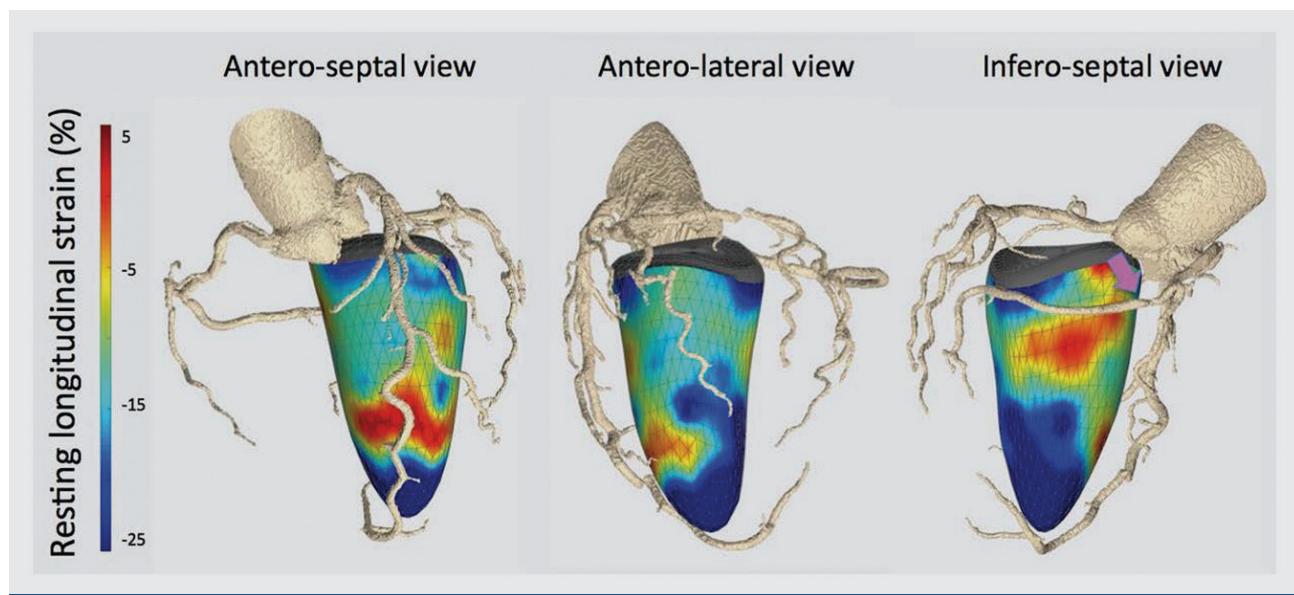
Fusion imaging of coronary CTA and three-dimensional speckle tracking echocardiography to assess the functional consequences of coronary stenosis. Combined three-dimensional displays of speckle tracking and CTA, in a patient with >70% stenosis in the mid right coronary artery (purple arrow). The infero-septal view shows reduced LV longitudinal strain in the basal segment (colour-coded in orange shades) subtended by this coronary artery. In addition, note a diffuse calcified plaque in the proximal left anterior descending coronary artery present causing reduced LV longitudinal strain in the mid-apical segments of the antero-septal view.
